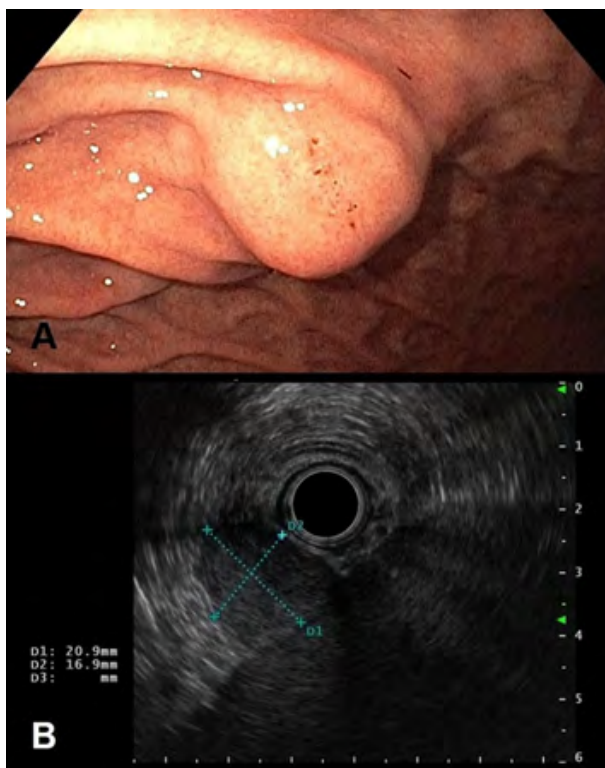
Preoperative gastroscopy. A: Bulging of the gastric wall into the gastric lumen with intact mucosal covering. B: Endoscopic ultrasound (EUS).
